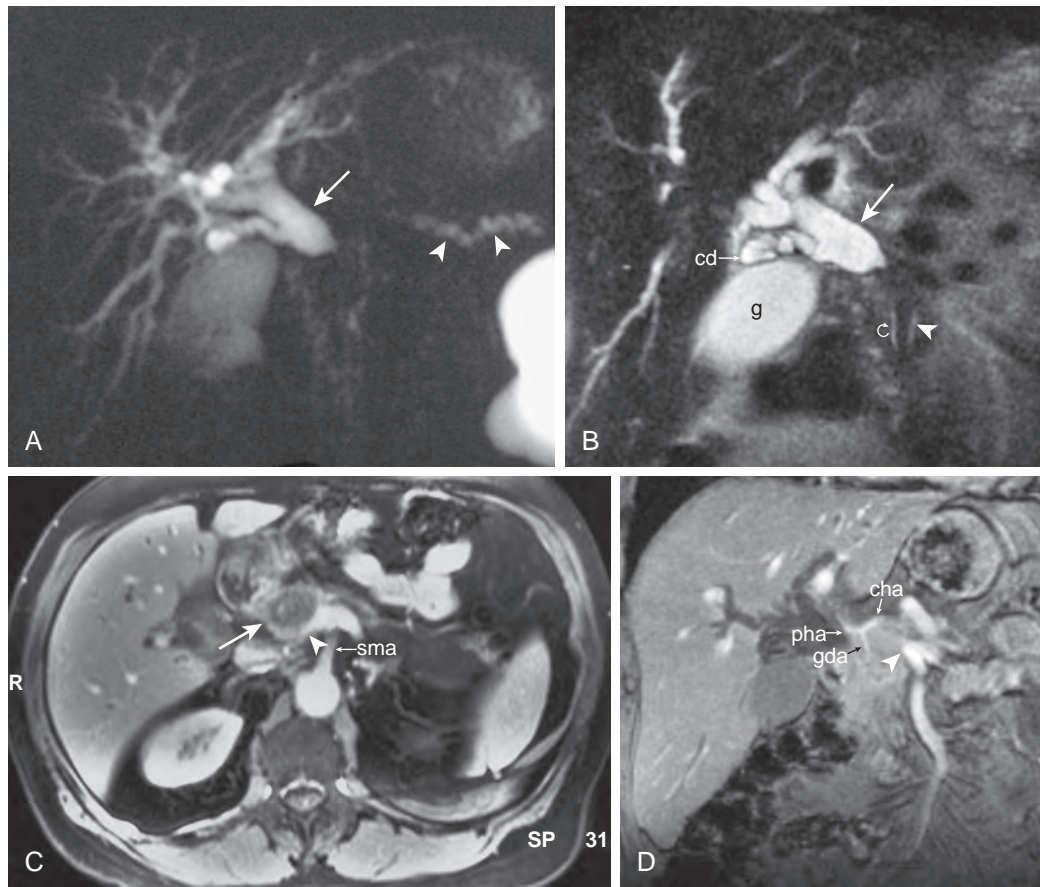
Unresectable pancreatic head carcinoma: MRCP, MRI, and MRA. A. Thick-slab MRCP provides a comprehensive image of the pancreaticobiliary tract that demonstrates high-grade obstruction of the extrahepatic bile duct (arrow) and minor dilation of the pancreatic duct (arrowheads) in the body and tail of the pancreas. B. Thin-slab MRCP reveals the finer details of the ductal systems and shows that the extrahepatic bile duct (arrow) is obstructed at the pancreatic head. The intrapancreatic portion of the bile duct (curved arrow) and the pancreatic duct (arrowhead) in the head of the pancreas are narrowed. The distended gallbladder (g) and cystic duct (cd) are shown. C. Transverse, T1-weighted, enhanced abdominal MRI shows that the cause of the obstruction is a low signal intensity pancreatic head carcinoma (arrow) that has occluded the distal superior mesenteric vein (arrowhead). There is no evidence of tumor surrounding the superior mesenteric artery (sma). D. Coronal, 2D time-of-flight MRI angiogram shows that the pancreatic head mass has occluded the distal superior mesenteric vein (arrowhead) and is inseparable from the common hepatic artery (cha), proximal proper hepatic artery (pha), and gastroduodenal artery (gda). (From Fulcher AS, Turner MA: MR cholangiopancreatography. *Radiol Clin North Am* 40:1367, 2002.)
